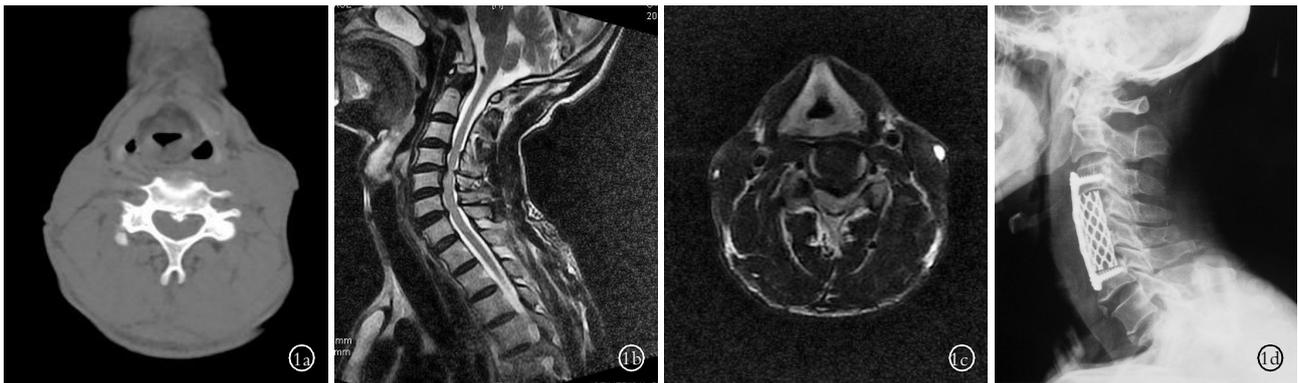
男性患者,58 岁,颈椎间盘突出致脊髓半切综合征 1a.C<sub>4</sub> 椎体后缘骨质增生并局部钙化 1b.MRI 显示 C<sub>3,4</sub>、C<sub>4,5</sub>、C<sub>5,6</sub> 椎间盘突出 1c.MRI 显示 C<sub>4,5</sub> 平面脊髓左侧半受压明显 1d.次全切除 C<sub>4</sub>、C<sub>5</sub> 并钛网植骨固定后的侧位片
